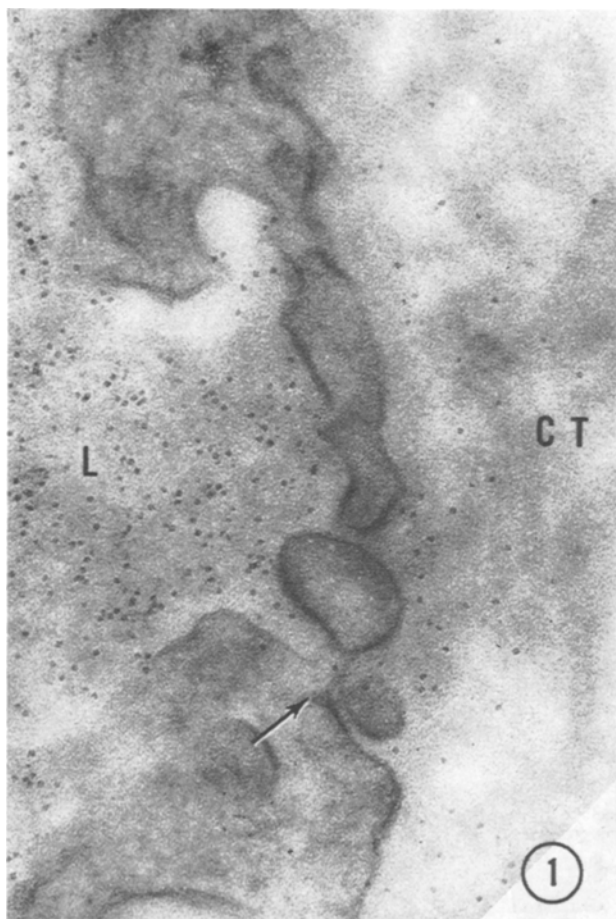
Arterial limb of a capillary in the jejunum. Ferritin was injected into the blood 4 min previously. Molecules are passing from the lumen (L) to the connective tissue (CT). There are two fenestrae, one which appears to have no diaphragm, and one (arrow) where a diaphragm is visible. There is a concentration of ferritin in the connective tissue just outside the fenestrae.  $\times 125,000$ .
